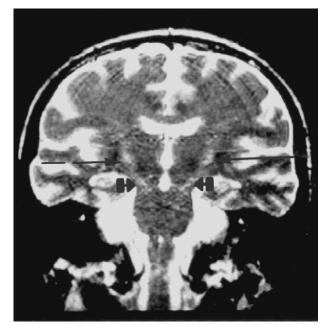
Coronal T2-weighted magnetic resonance imaging (MRI) demonstrating increased signal intensity in the substantia nigra extending to basal ganglia bilaterally and enlargement of the cerebral sulci.
